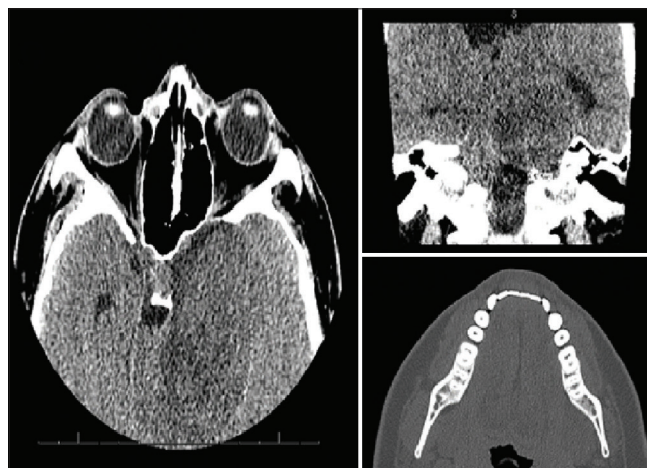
Diagnostic computed tomography maxillofacial images figure description: images a and b demonstrate axial and coronal views of a $5.2 \times 6.6 \times 4.3$ cm intra-axial mass with compression and displacement of the brainstem. Image C demonstrates an axial view of the mandible, showing asymmetry of the left mandibular ramus and muscular hypotrophy on the left side.
